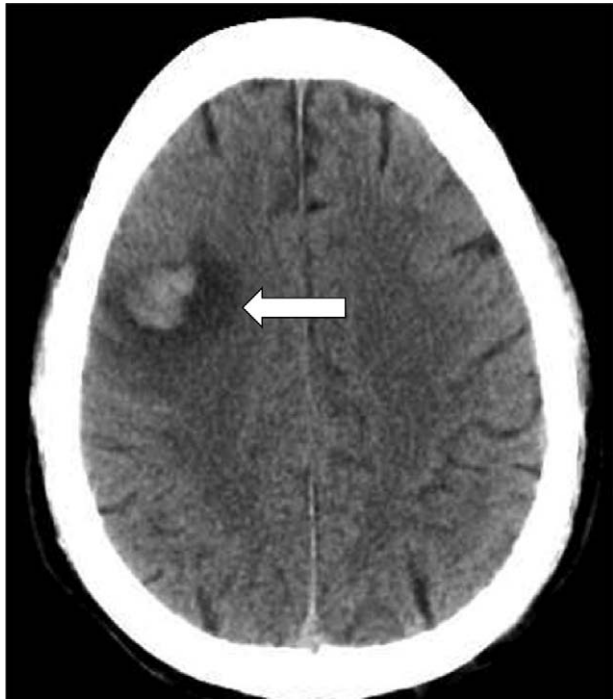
Computed tomography (CT) scan reported cerebral hemorrhage in the right parietal and frontal lobe (white arrow).
